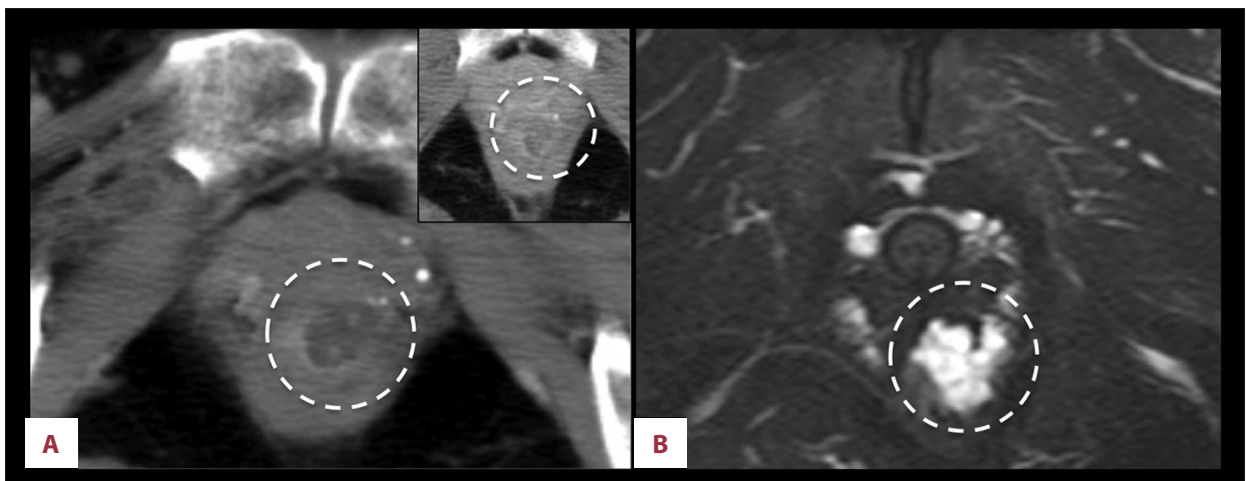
Radiology findings. (A) CT showed an 18-mm isodense perianal fluid collection on the anterior rectal wall (circle). The inset in the top right corner shows the results of CT performed at 10 months. A perianal fluid collection around the same lesion remained, but it was 7 mm at that time. (B) MRI showed a multiple conglomerated cystic mass at the same location with no invasion of the vaginal wall (arrow).
